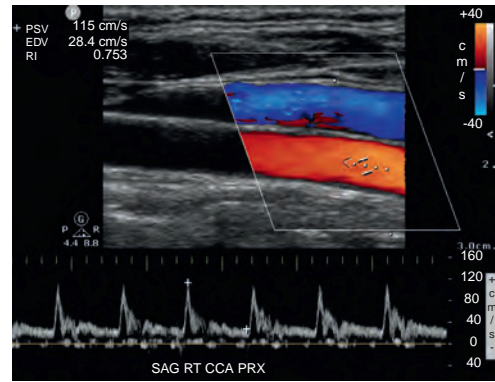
The spectral display shows the distribution of Doppler frequencies versus time. This is displayed as velocity on the vertical axis and time on the horizontal axis. Flow toward the transducer is displayed above the baseline, and flow away from the transducer is displayed below the baseline.
